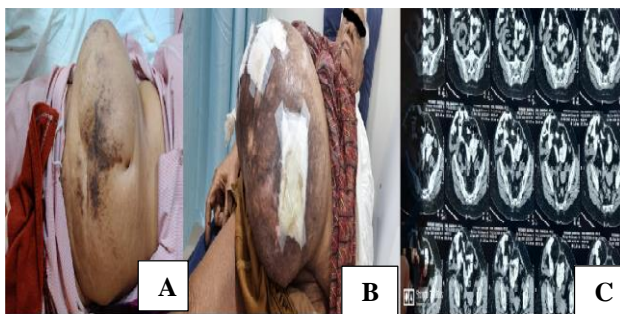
(A) loss of domain hernia with colour changes over abdominal wall; (B) loss of domain hernia; and (C) CT images showing herniation of bowel loops with unhampered vascularity.
